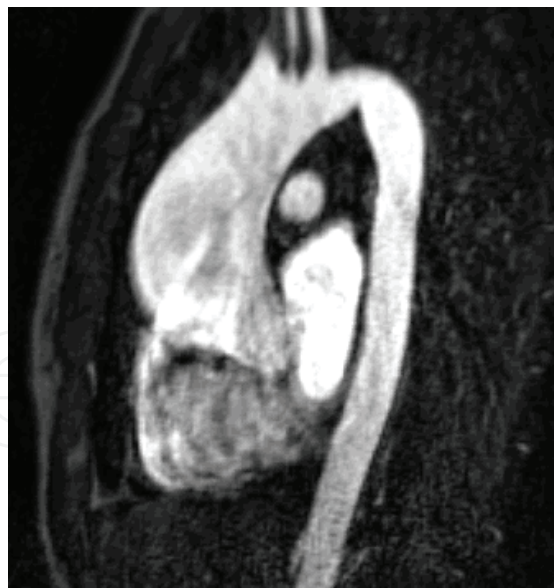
Magnetic resonance imaging demonstrating an asymmetric mid-ascending aortic aneurysm in a patient with BAV stenosis
